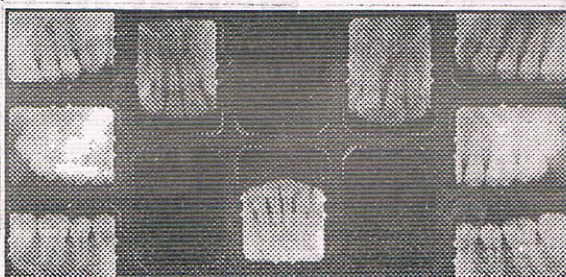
Postoperative IOPA X-Rays
